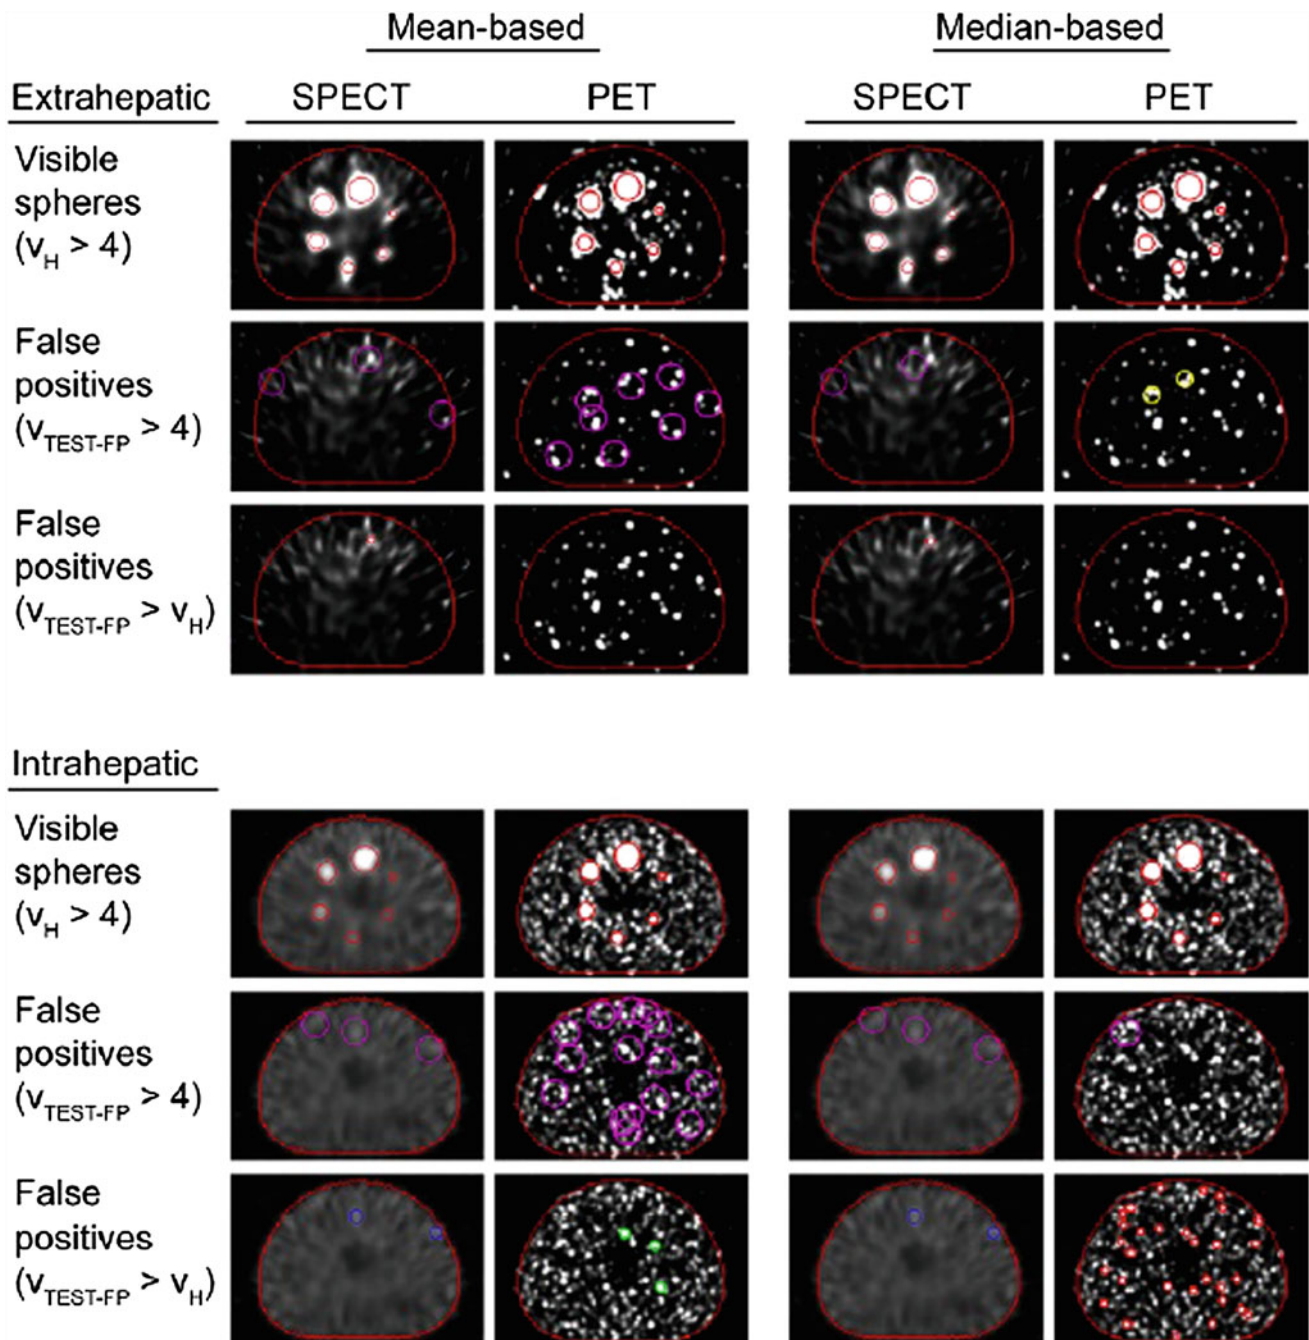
A visual comparison of FDG-PET versus SPECT imaging for the assessment of intrahepatic and extrahepatic microsphere distribution after radioembolization. FDG-PET imaging often has superior
